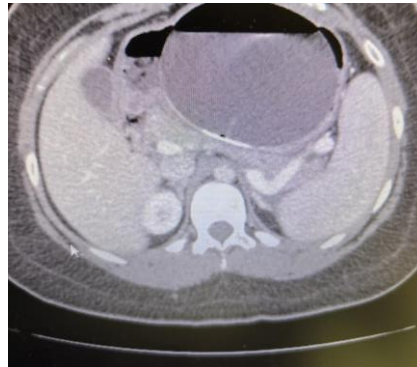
Imaging of the computed tomography of the patient's abdomen and pelvis.
